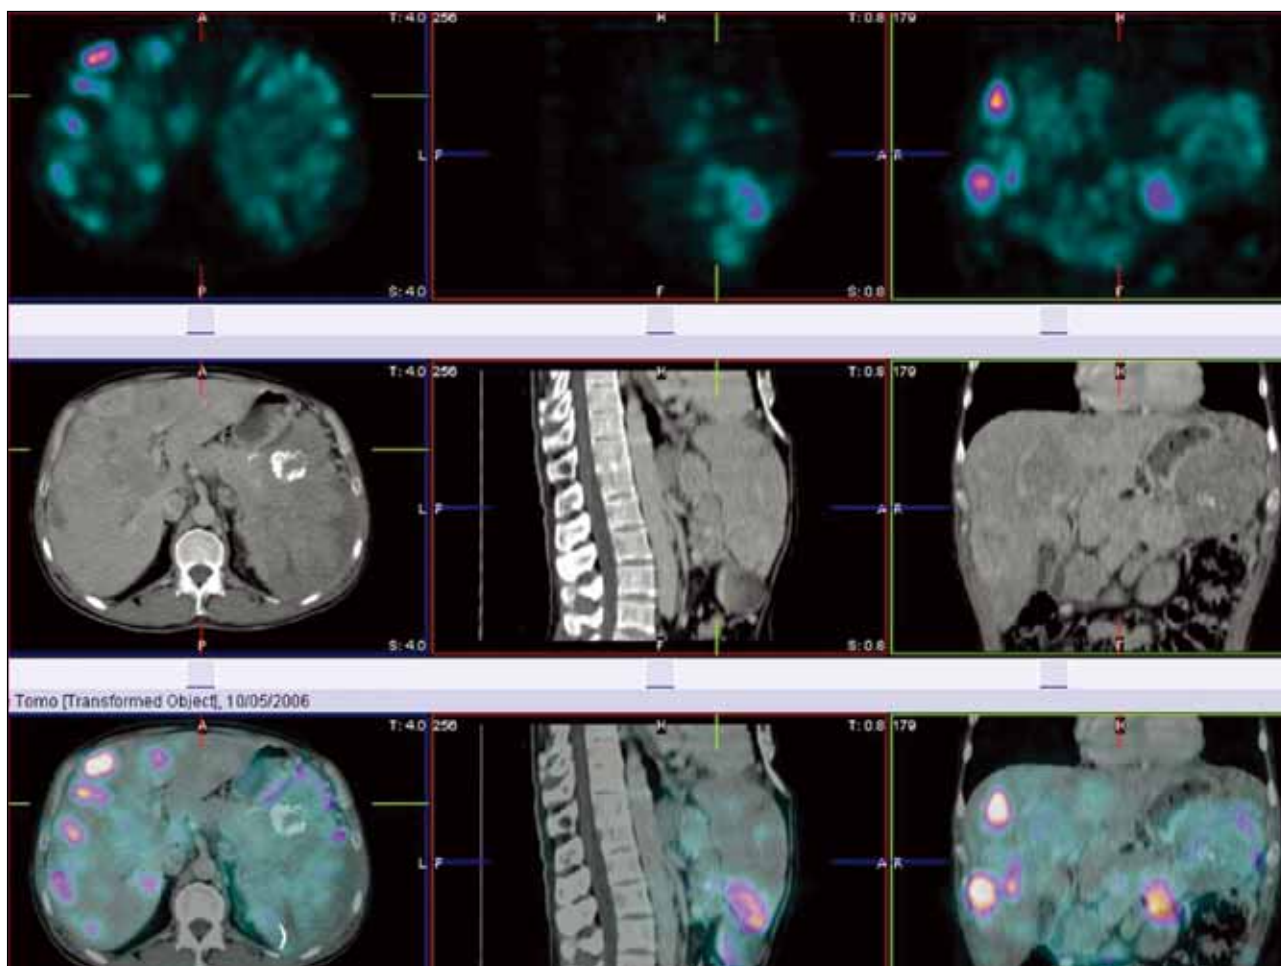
A patient with pancreatic neuroendocrine tumour showing good uptake of ^{99m}Tc -EDDA/HYNIC-octreotate images in multiple liver metastases (in the top row) compared with computed tomographic images (in the middle row) and fused images (in the bottom row). Images courtesy of Dr Cwikla, Warsaw, Poland.
